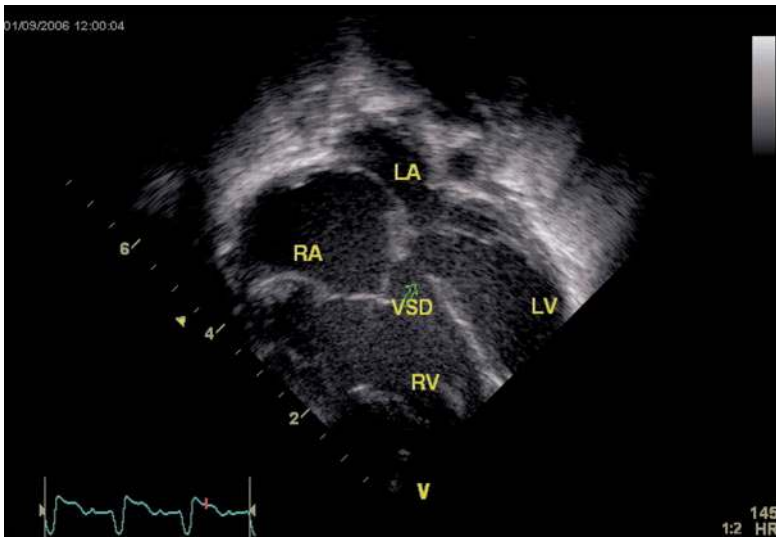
Apical four-chamber view demonstrating an inlet ventricular septal defect
